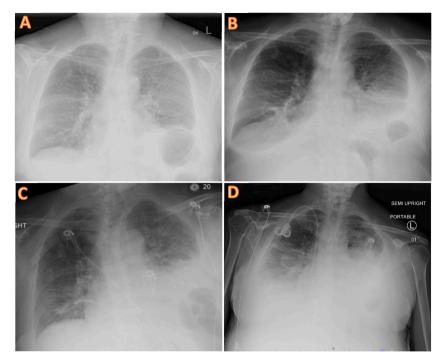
(A) Frontal chest radiograph (CXR) taken 1 month prior to hospital admission showing elevated left hemidiaphragm with no evidence of pleural effusion. Elevated left hemidiaphragm had been present on prior imaging studies. (B) Initial CXR from first hospital admission showing bilateral pleural effusions confirmed by subsequent computed tomography. (C) CXR obtained after right thoracentesis showing improvement of right pleural effusion with similar left pleural effusion. (D) CXR from second hospital admission showing recurrence of right pleural effusion and worsening left pleural effusion.
